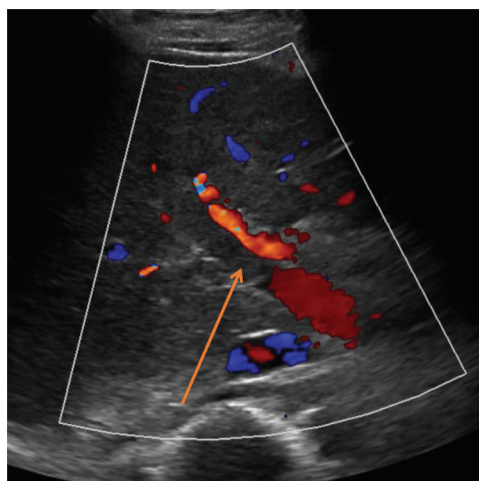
Ultrasound color Doppler.
